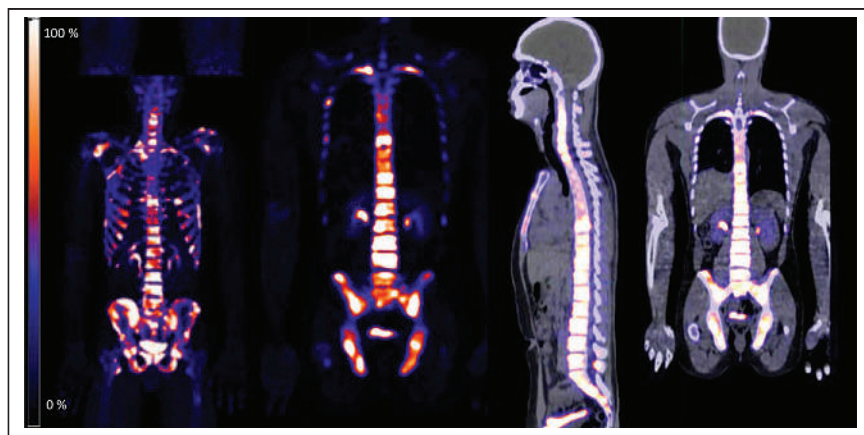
^{18}F -fluoride PET/CT scan. Diffuse bony metastasis with intense ^{18}F -fluoride uptake is seen. From right to left maximum-intensity-projection PET, coronal PET, sagittal PET/CT, and coronal PET/CT images.
